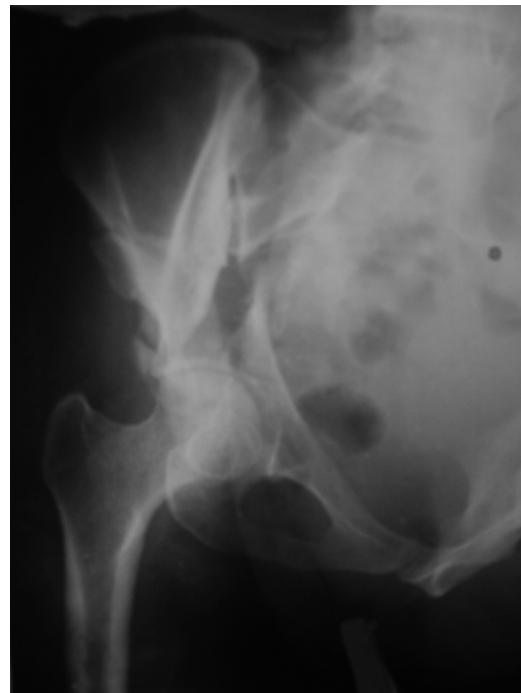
Pre-operative anteroposterior radiograph of hip showing bicolumnar fracture
